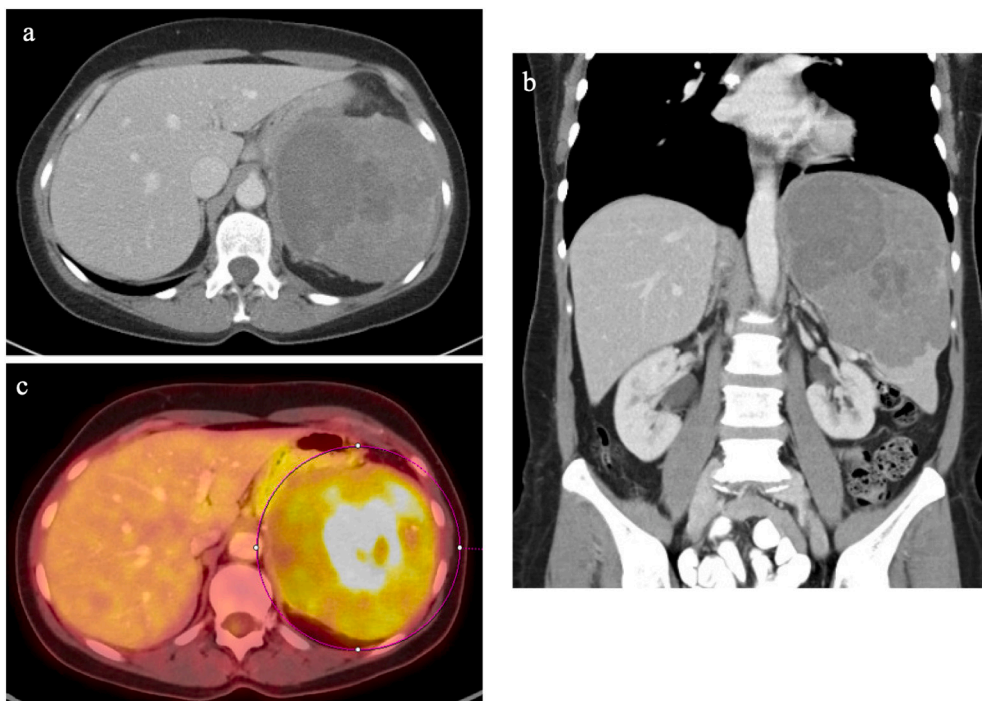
Radiographic images from Case 1. a, b) Transverse and coronal sections from a CT of the abdomen and pelvis demonstrating a low-density mass in the spleen that measures $14.6 \times 11.0 \times 11.2$ cm. The lesion involves the majority of the spleen sparing the inferior tip. More superiorly there is an 8 cm rounded area of slightly decreased density that could represent an area of necrosis or fluid. c) Fluorodeoxyglucose (FDG) positron emission tomography (PET) scan reveals a large heterogeneous mass in the spleen. There is necrosis in the medial aspect of the lesion and the solid portion demonstrate a maximum standardized uptake value (SUV) of 8.0.
